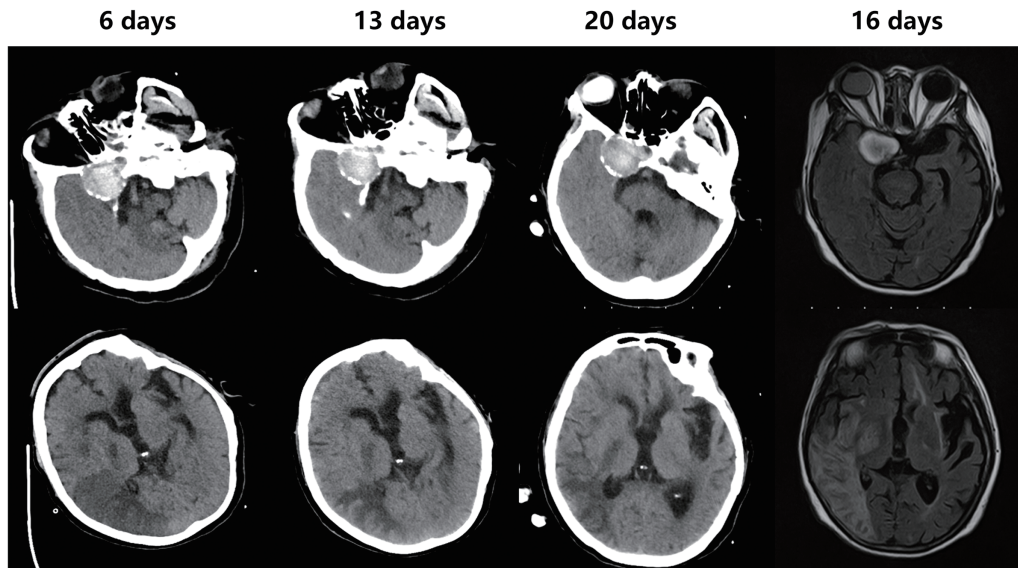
Follow-up head CT and MRI at different times showed cerebral infarction in the right temporal lobe.
